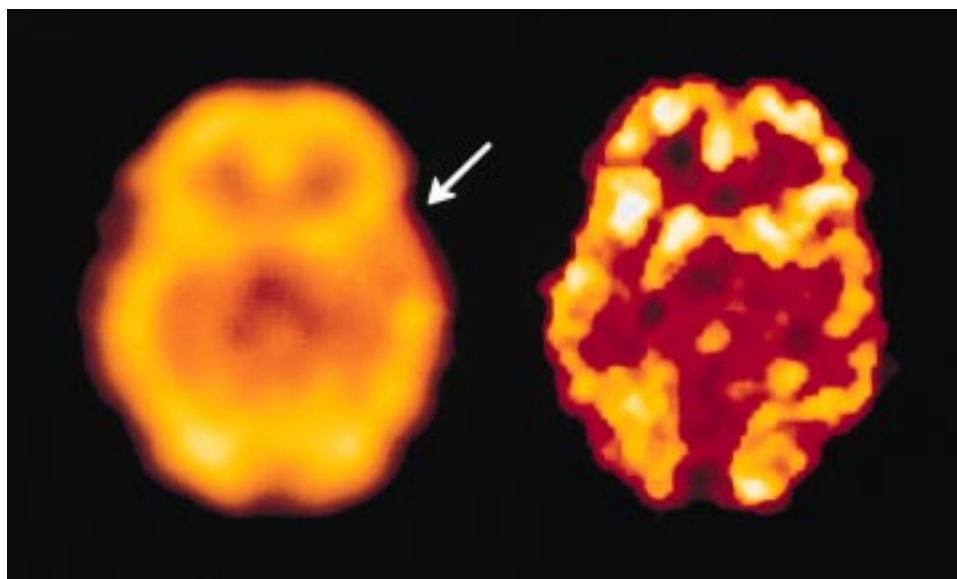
Example of ECD-SPECT (a) and FDG-PET (b) images depicting a 15% perfusion defect in the anterotemporal cortex (arrow), and a symmetrical accumulation of FDG in the cortex at the same level.
